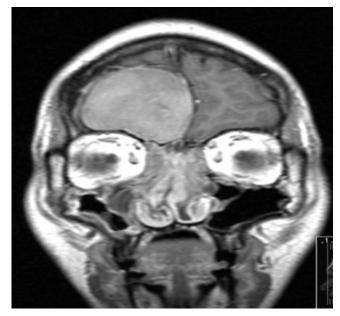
Coronal CT showing asymptomatic intracranial extradural chronic collection of insipissated mucus in patient with nasal polyposis.
